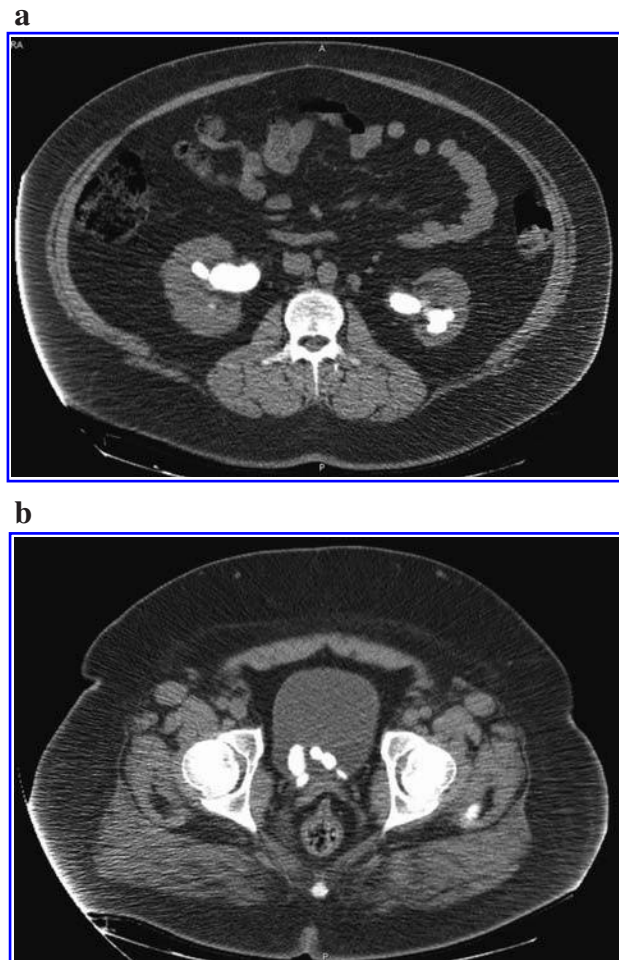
CT (a, b) demonstrates the proximal and distal ends of a completely encrusted stent from a patient whose severity of encrustation was significantly underestimated by plain radiography. Stone composition on the stent was uric acid.
